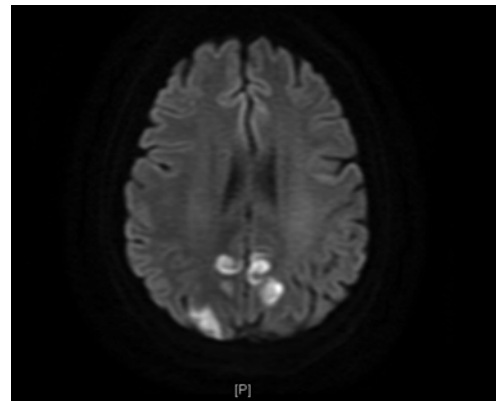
(above): MRI Brain
